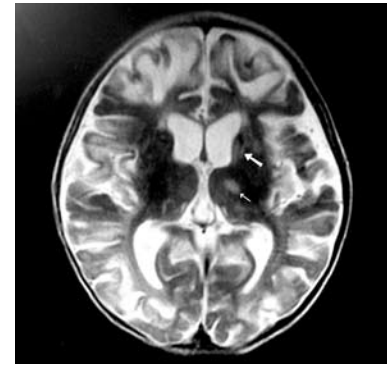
Brain MRI of the patient at the age of 7 months, axial T2 weighted image showing increased signal intensity in the caudate nucleus (thick arrow), left thalamus (thin arrow) and white matter.
